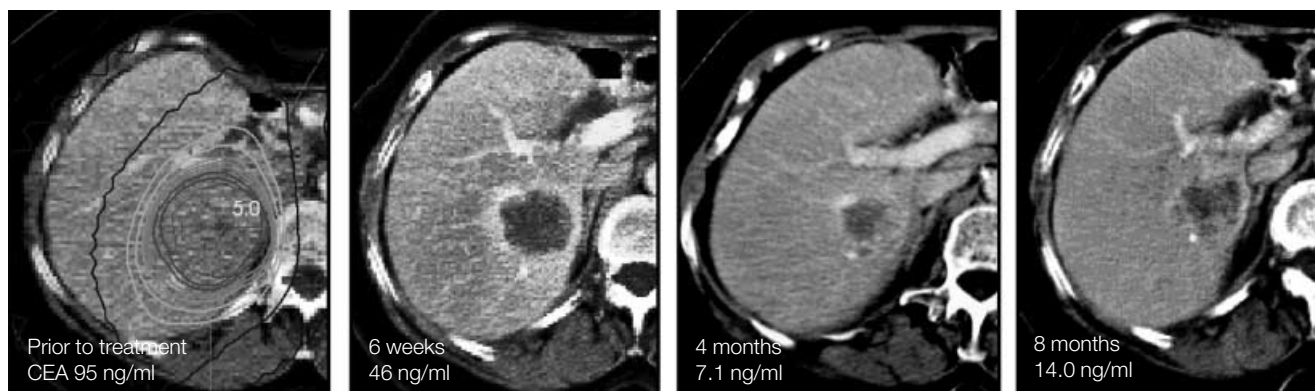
66-year-old female with a metachrone solitary liver metastasis of rectal cancer, who had undergone resection of solitary metastases 1 and 2 years prior to radiotherapy. Stereotactic irradiation was performed with three fractions of 10 Gy, normalized to the PTV enclosing 65%-isodose. CTV and PTV were 194 cm³ and 310 cm³. The CT scans during follow-up showed after initially typical reaction of tumor necrosis with a contrast enhancing resorption zone (6 weeks) and slow tumor shrinking (4 months) a recurrence of new tumor nodules within the high-dose area after 8 months. Tumor remission and recurrence correlated to decrease and rise of CEA level.
